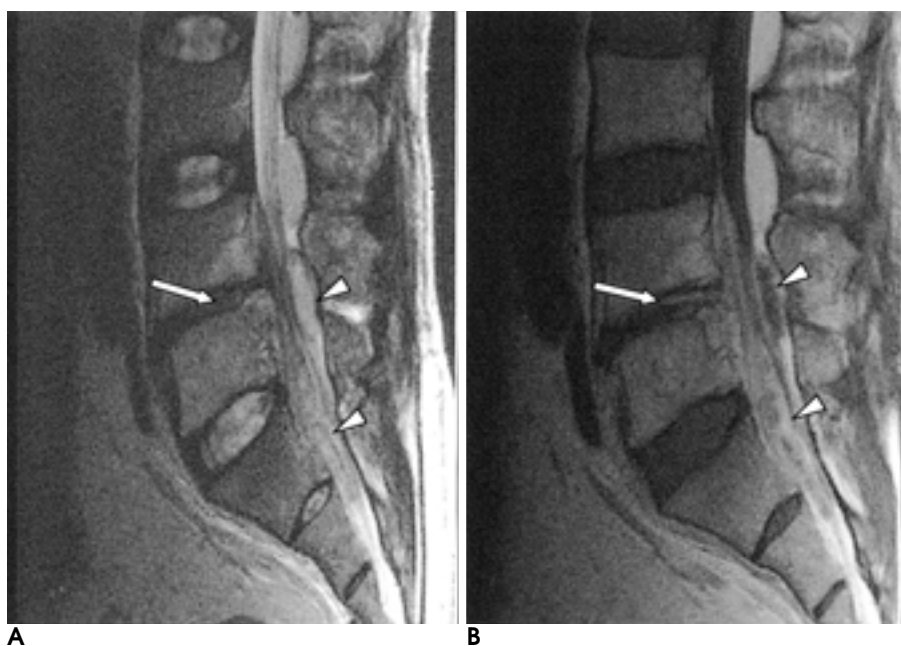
A 58-year-old man with lumbar pyogenic abscess. Sagittal T2- (A) and contrast enhanced sagittal T1-weighted (B) images show L4/5 discitis (arrow), spondylitis and epidural abscess (arrow heads) compressing the thecal sac.
